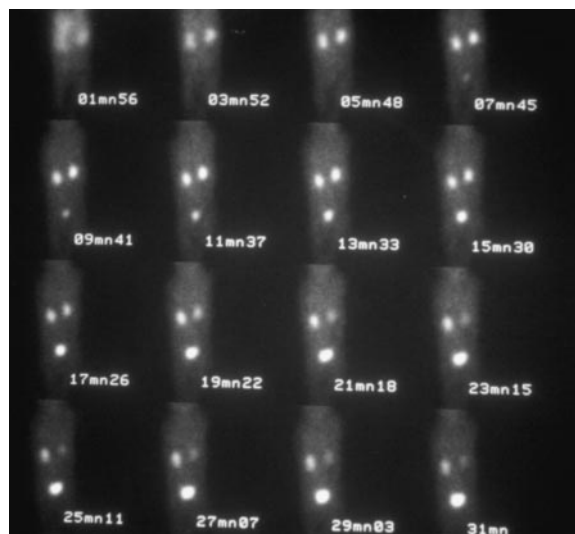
Renal scintigraphy of twin L over 30 min using $^{99}\text{Tc}^{\text{m}}$ DTPA.
